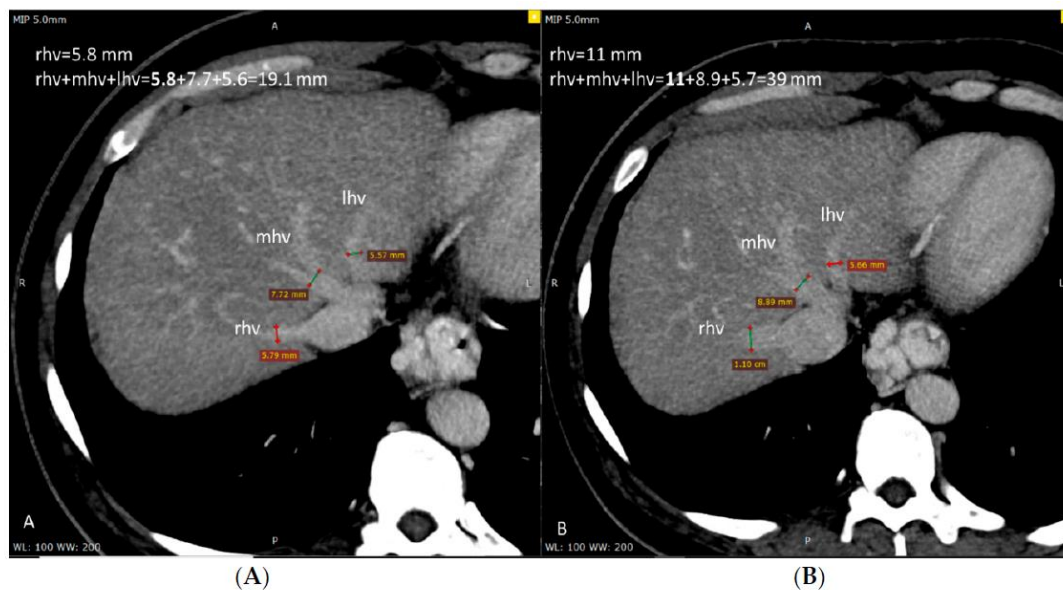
Computed tomography (CT) axial section at the level of hepatic veins before (A) and after (B) treatment. Only the right hepatic vein (rhv) showed significant widening after treatment (11 mm) compared to before (5.8 mm), while the middle hepatic vein (mhv) and left hepatic vein (lhv) showed no significant changes
